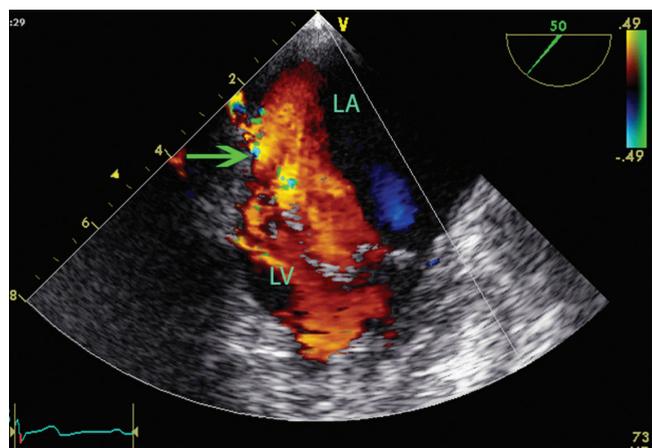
Transesophageal echocardiography in the long-axis view (50°) shows MR originating from the base of the PMVL (P3) (arrow).
